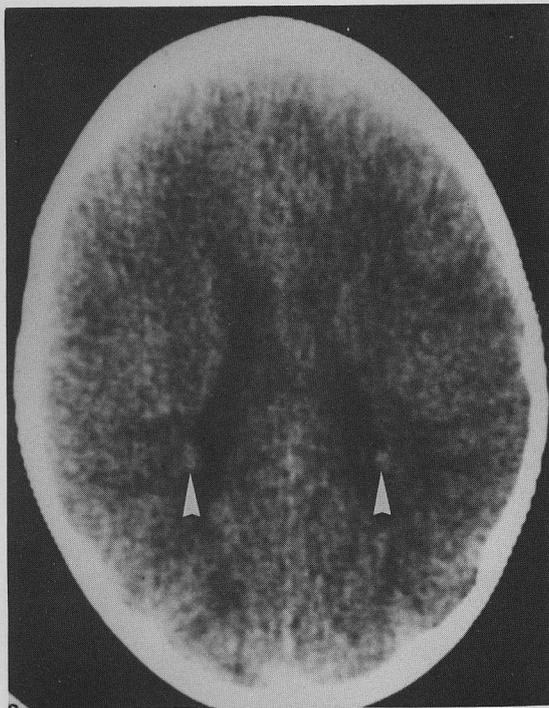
Evidence of heterotopias of gray matter in periventricular area. CT, axial section, case 1.
